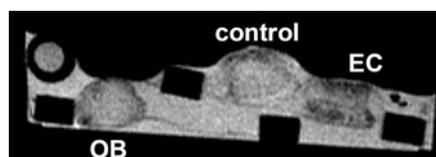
MRI analysis of monocultures only (OB = osteoblasts, EC = endothelial cells) and control (no seeding). The round object in the left upright corner is the reference tube, whereas the black squares are the plastic rings that were used for stabilizing the scaffolds on the CAM membrane.
